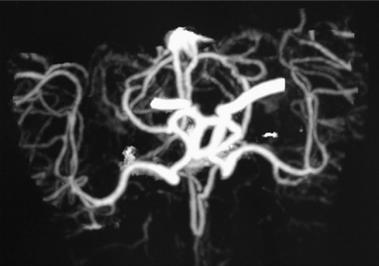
Digital subtraction angiography (DSA) and computed tomography angiography (CTA). Digital subtraction angiography (DSA) and computed tomography angiography (CTA) of the patient, performed on the latest follow-up on May 8th, 2017. Both internal carotid arteries were completely occluded, there was no distal flow of the dye, and the entire Willis circle was complete enhanced with the vertebral-basal arteries significantly enlarged. Single column fitting image.
